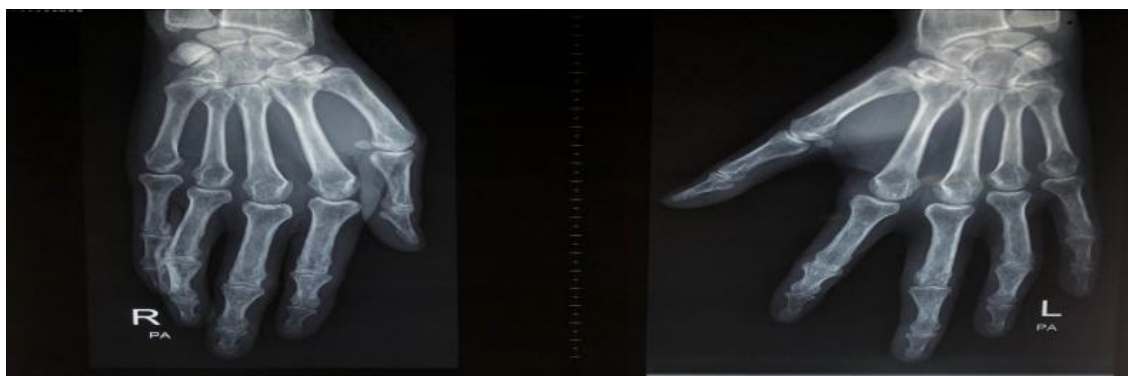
Radiography of the hands showed interphalangeal space narrowing which indicated arthritis, classic findings of pencil in cup deformity and bony proliferation were not found in this case
